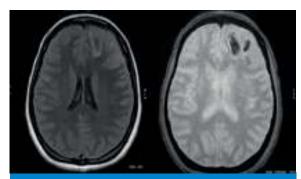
& 8 T2 FLAIR & GRE images: Showing mixed intense area noted in left frontal lobe in T2flair, blooming noted in left frontal lobe in GRE.
